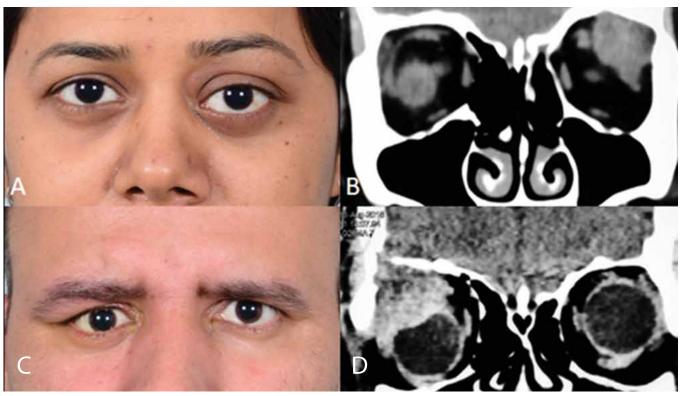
(A) Left proptosis (B) Coronal CT reveals a left supertemporal homogenous orbital mass in the lacrimal fossa, with bony indentation and no bone destruction which on biopsy proved to be pleomorphic adenoma. (C) Right proptosis (D) Coronal CT shows a non-homogenous ill-defined mass lesion in the right lacrimal fossa with evidence of bone destruction which on biopsy proved to be adenoid cystic carcinoma of the lacrimal gland.
